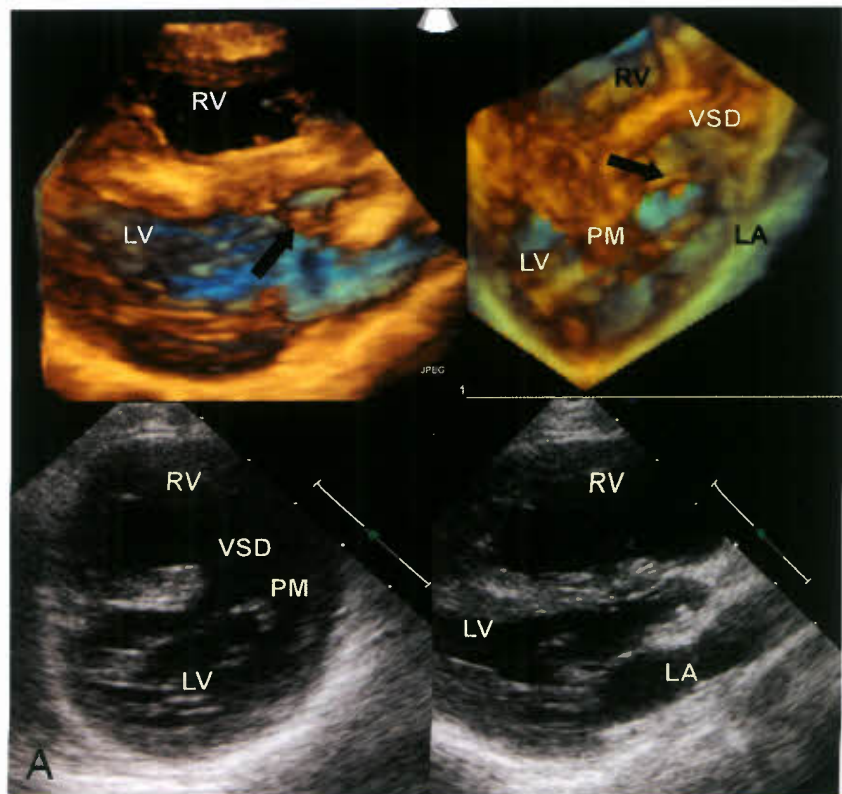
A: This montage shows a straddling MV as seen by two and three-dimensional echocardiography. The two lower images show the mitral chords inserting into a papillary muscle; however, the precise location is unclear. The upper right hand image is similar to the upper left one, but with slight angulation to show the anterior muscular ventricular septal defect with the chordae from the MV inserting into it. LA, left atrium; LV, left ventricle; PM, papillary muscle; RV, right ventricle; VSD, ventricular septal defect.
